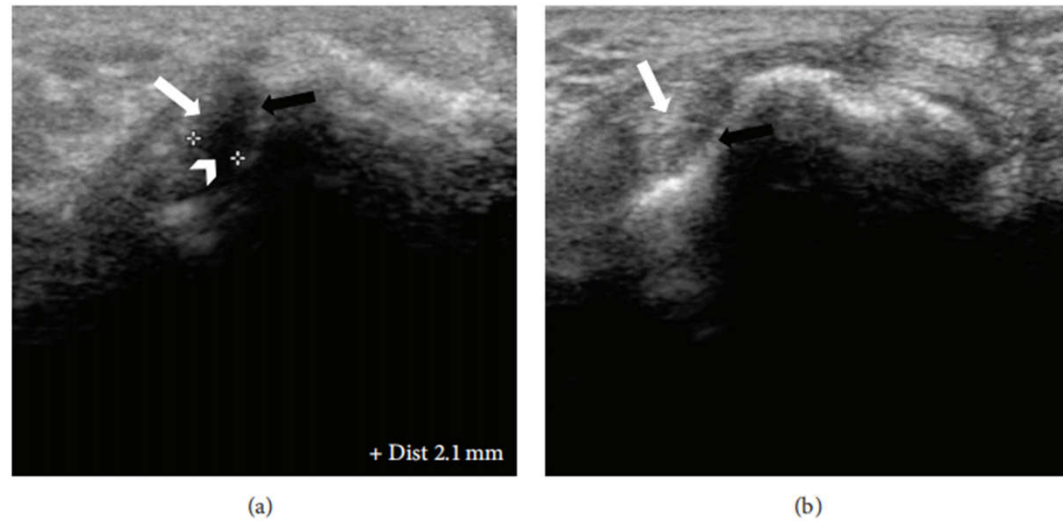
Dorsal ultrasound images of MCPJ at bare areas. (a) Radial recess shows distinct hypoechoic synovium (*arrow head*) compared to displaced hyperechoic proper collateral ligament (*white arrow*) and bone (*black arrow*). Calipers are being used to measure the maximal synovial thickness at this region with characteristic appearance on ultrasound. (b) shows no synovial thickening between the proper collateral ligament (*white arrow*) and adjacent to cortical bone (*black arrow*).
